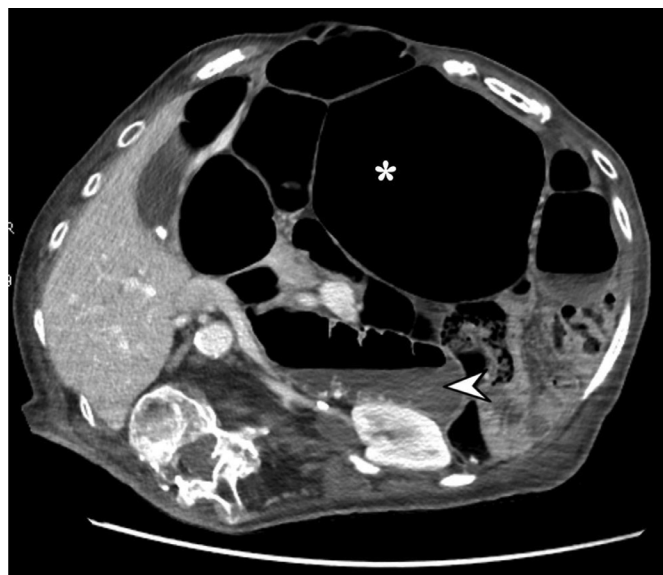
Axial abdominal contrast-enhanced CT. The scan obtained in portal-phase shows sigmoid (asterisk) and duodenum dilatation, with formation of an air-fluid level (arrowhead).
